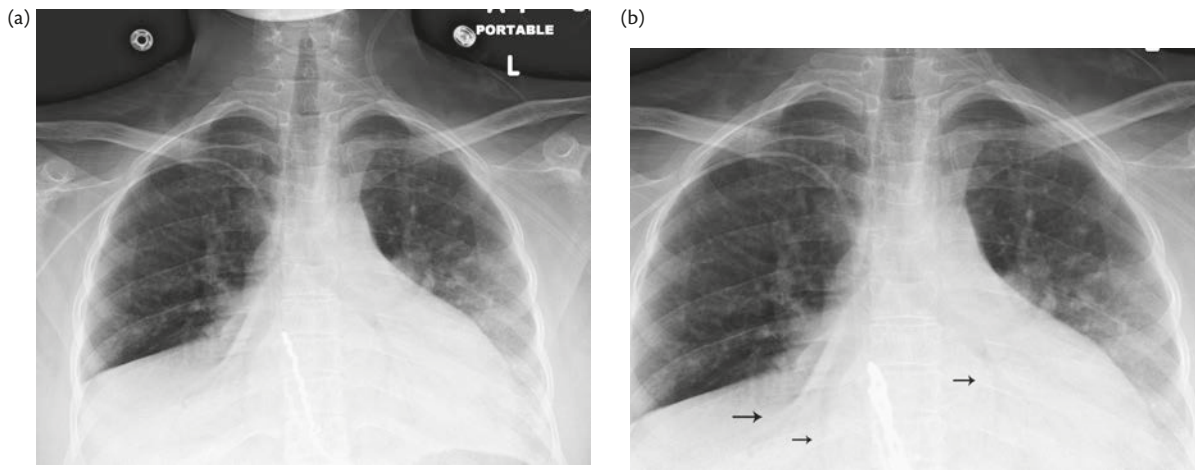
Case 5. (a) X-ray; (b) X-ray (arrows show air bronchograms indicating patent airways).
